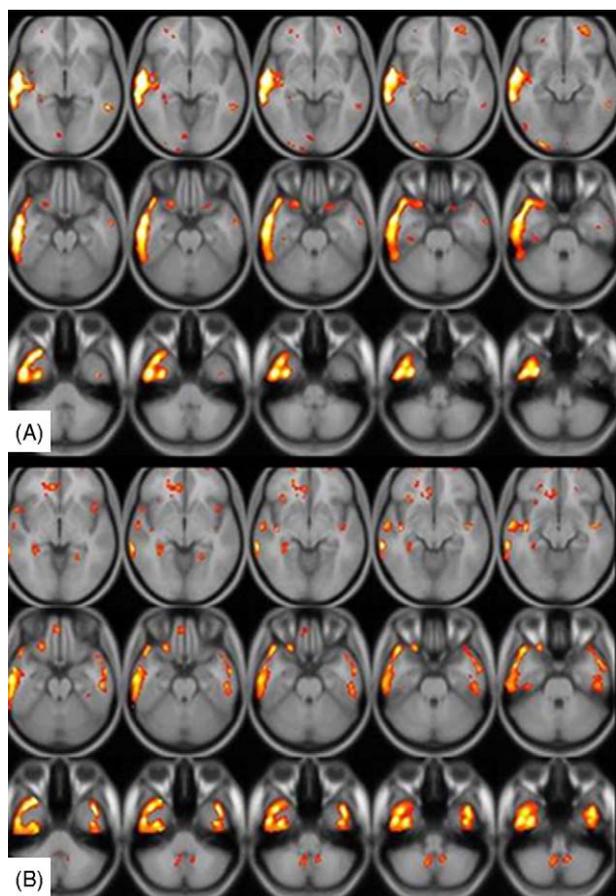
(A) Unilateral temporal hypometabolism (UTH). Statistical parametric mapping (SPM) analysis of ^{18}F -FDG PET shows the decreased metabolism in right temporal lobe (Patient 24 in Table 1). (B) Bilateral temporal hypometabolism (BTH). Statistical parametric mapping analysis of ^{18}F -FDG PET shows the decreased metabolism in bilateral temporal lobes, which is more prominent in the right side (Patient 28 in Table 1).
